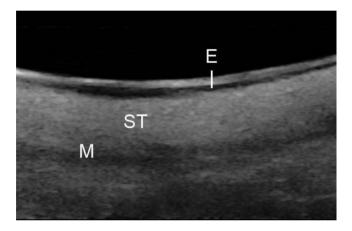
Ultrasonography image of pSS patient reveals decreased thickness and heterogeneous hyperechogenicity of buccal mucosa. E = epithelial membrane of buccal mucosa; ST = subepithelial connective tissue; M = buccinator muscle.
